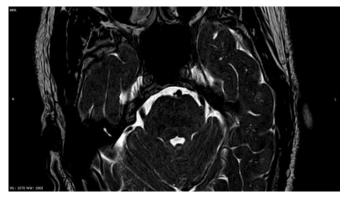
T2W axial MRI image shows thinned out and laterally displaced left trigeminal nerve at its root exit zone by a branch of superior cerebellar artery suggestive of neurovascular compression syndrome
